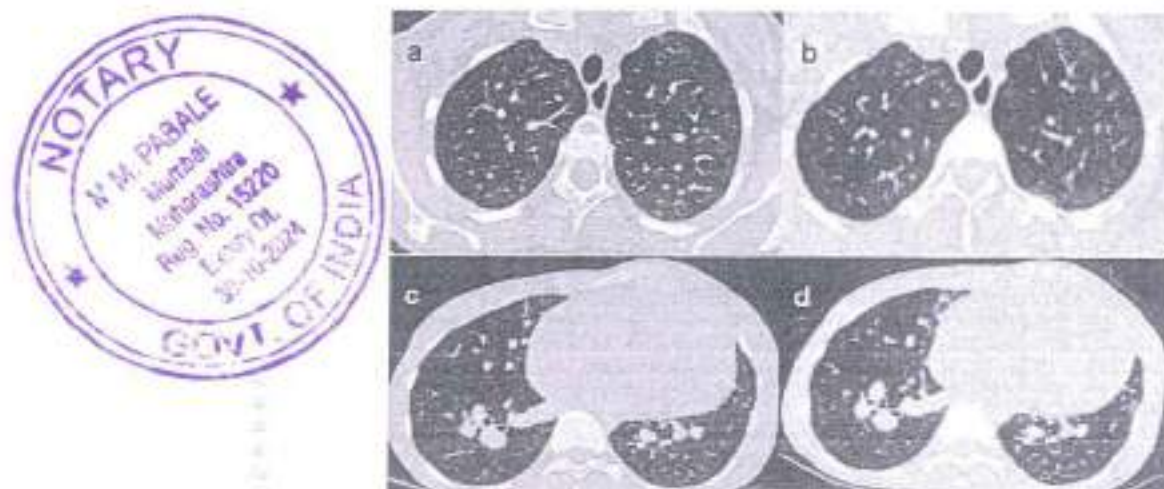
Chest CT images of Case A. Figures a and c were taken on February 11, which showed non-COVID-19 imaging feature. Case A underwent a CT scan again on February 22. Figures b and d, the follow-up images, showed no significant differences than before.
